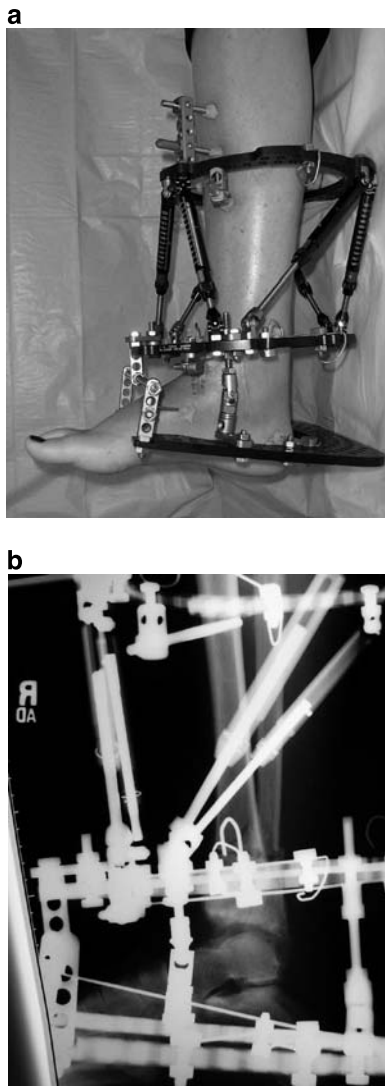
a, b Side view and x-ray of a patient who underwent a supramalleolar osteotomy for deformity correction and simultaneous ankle distraction
